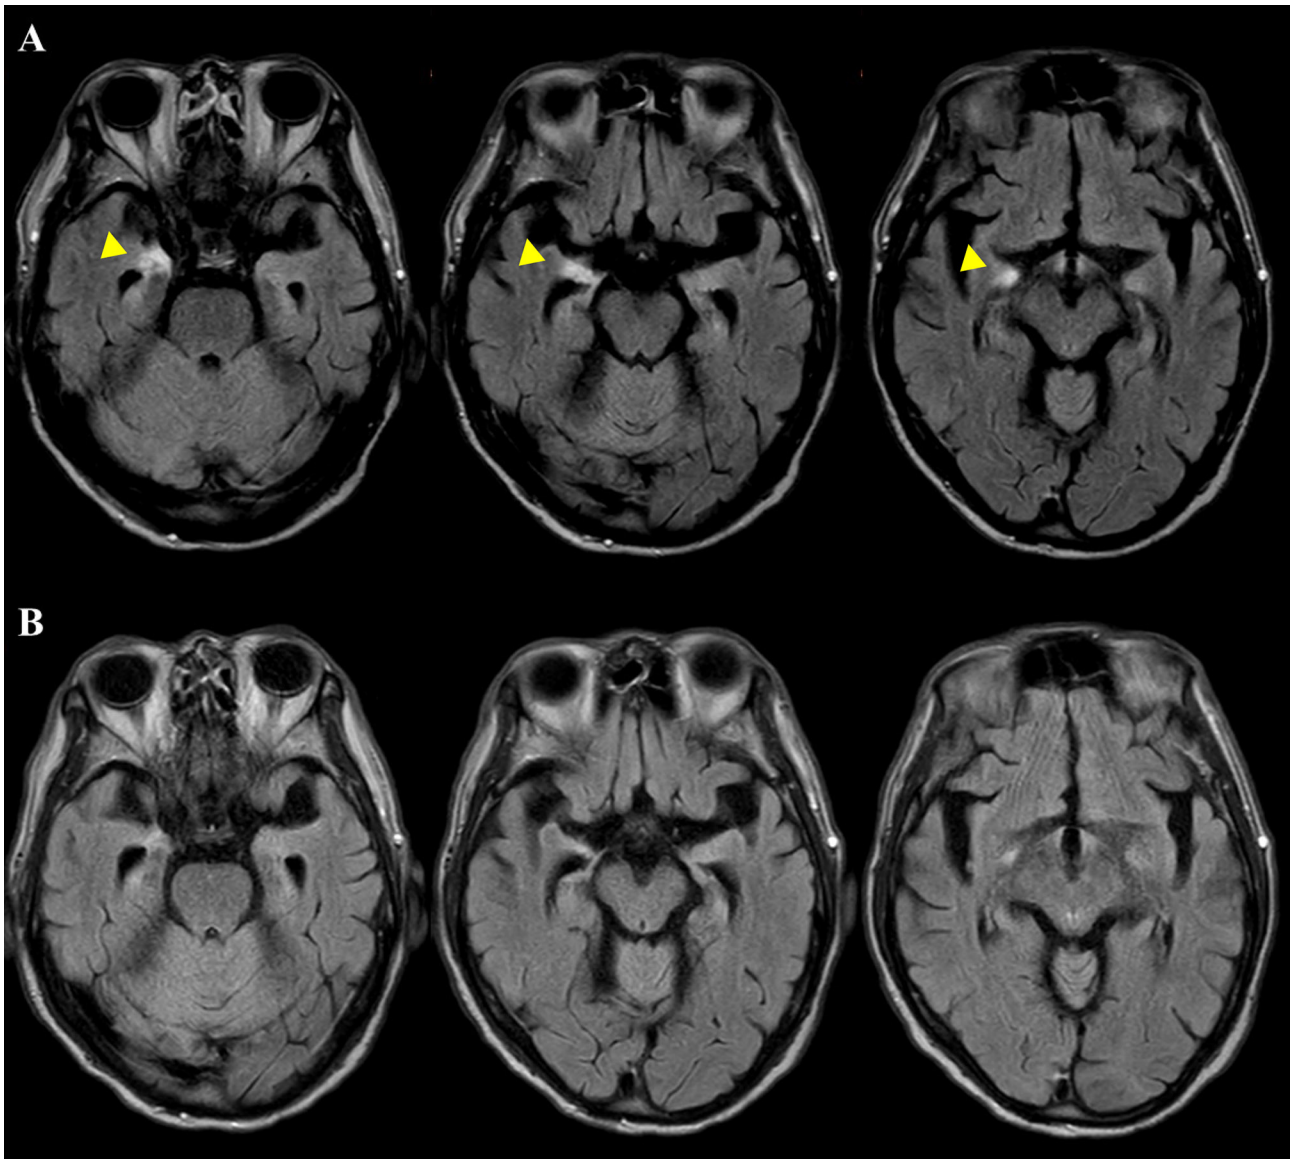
Brain magnetic resonance imaging (MRI) findings of nivolumab-associated limbic encephalitis. (A) Axial fluid attenuated inversion recovery (FLAIR) image at the time of symptom onset showing hyperintense signal in the right hippocampus, consistent with limbic encephalitis (yellow arrow). (B) Follow-up MRI obtained three months after nivolumab discontinuation demonstrating resolution of the hippocampal hyperintensity, corresponding with clinical improvement of cognitive symptoms.
